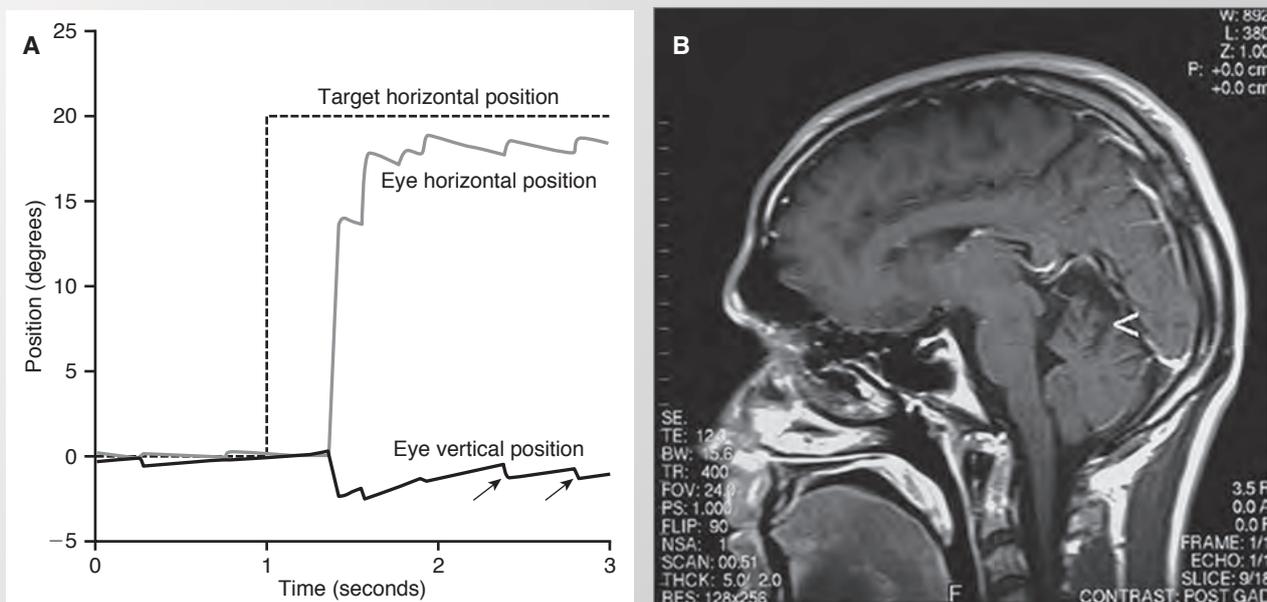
Disturbances of eye movements with cerebellar disease. Positive values indicate rightward or upward movements. (A) Case History 14-1: A patient with episodic ataxia type 2 (EA-2) developed gaze-evoked nystagmus with a down-beating component (arrows) as he shifted gaze to a target jump to right 20 degrees. (B) Midsagittal MRI showing some atrophy (arrowhead) in this patient with EA-2.
